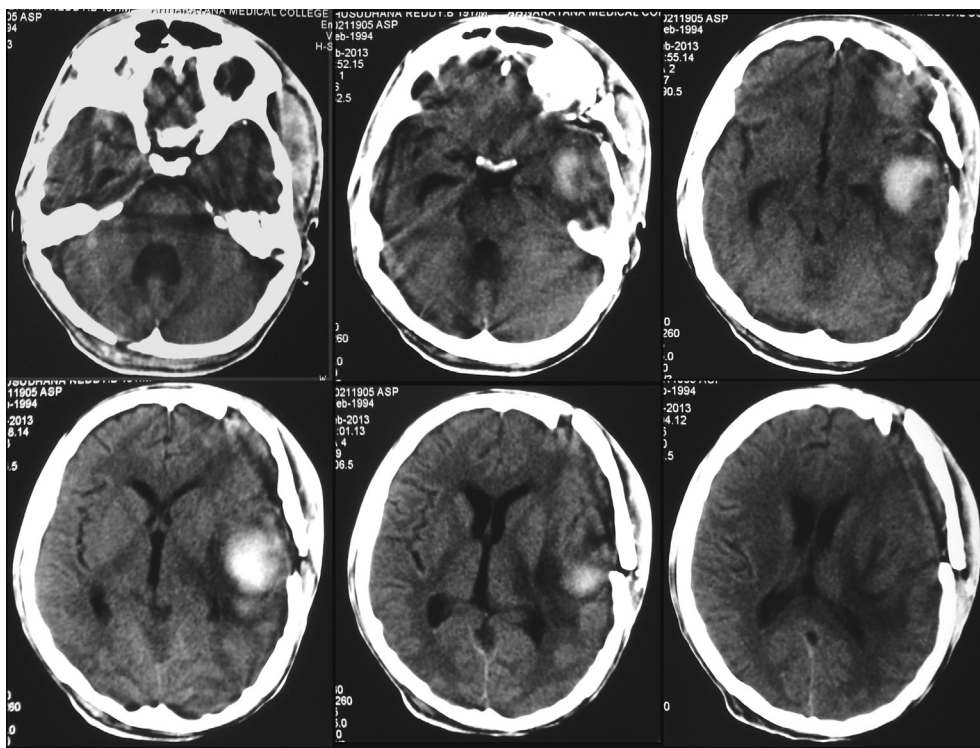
Follow up CT scan at 2 weeks showing good resolution of cerebellar and frontal hematomas and resolving left temporal lobe hematoma, please note significant resolution of the mass effect and midline shift.
